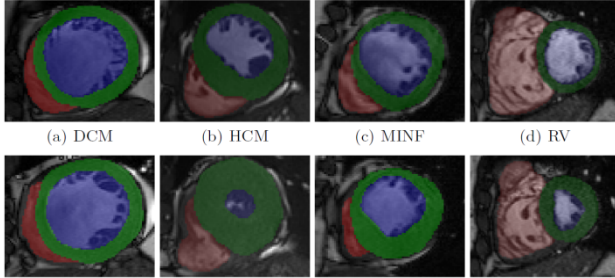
Examples of cine-MRI images for the four abnormalities (Top: ED, bottom: ES)
